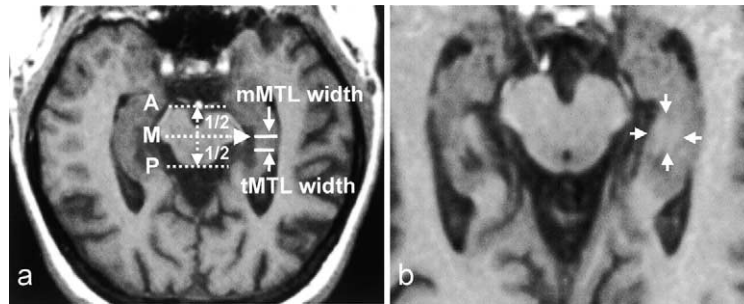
(a) Methodology of linear measurements of the MTL width. All measurements were taken in the axial MR image at the level of the ICS between the anterior (A) and posterior (P) borders of the midbrain. mMTL width is the width at the point midway (M) between the anterior–posterior borders of the midbrain. tMTL width is the thinnest width at any point between the anterior–posterior borders of the midbrain. (b) An axial MRI slice at a level through the middle of the SC (SC-b level), parallel to the LAH shows that the left inferior thalamus, a structure outside the MTL (small arrows), becomes apparent and is hard to separate from the surrounding hippocampus. The inferior thalamus should not be included in the linear measurement.
